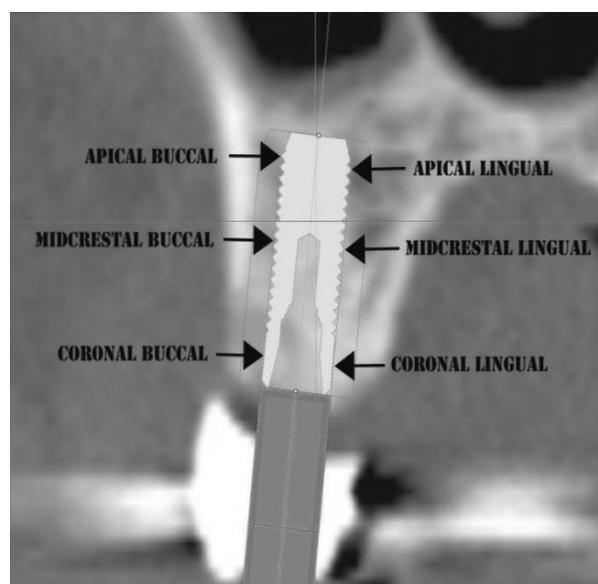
Quantification of Mean Bone Density using CT at the coronal, midcrestal, and apical regions of the dental implant.
